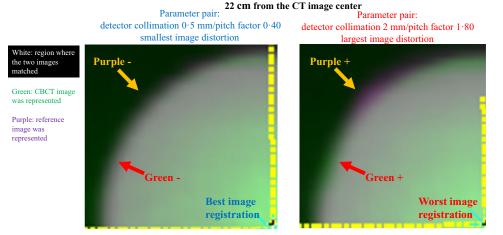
The reference image with the largest image distortion did not match the CBCT image. CBCT, cone-beam computed tomography; CT, computed tomography.
